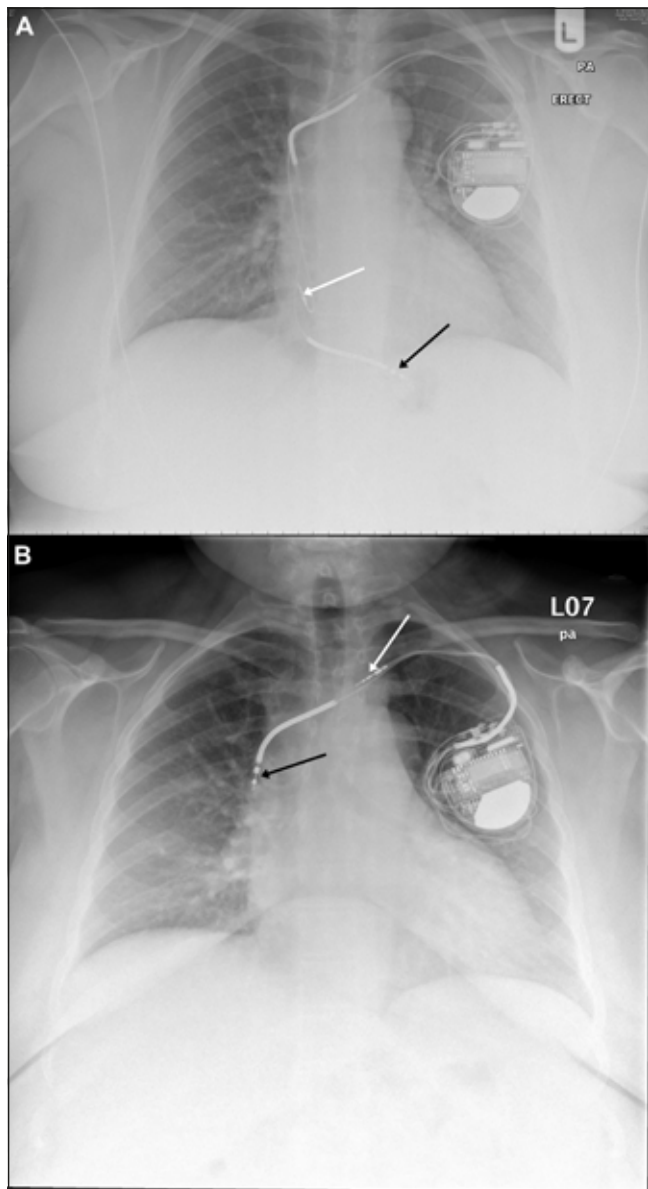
Panel A: Chest X-ray one day after implantable cardioverter defibrillator (ICD) implantation demonstrating satisfactory position of atrial lead (white arrow) and ventricular lead (black arrow). Panel B: Chest X-ray four weeks after ICD implantation demonstrating retraction of atrial lead (white arrow) and ventricular lead (black arrow) and loops of redundant lead in the region of the ICD generator.
